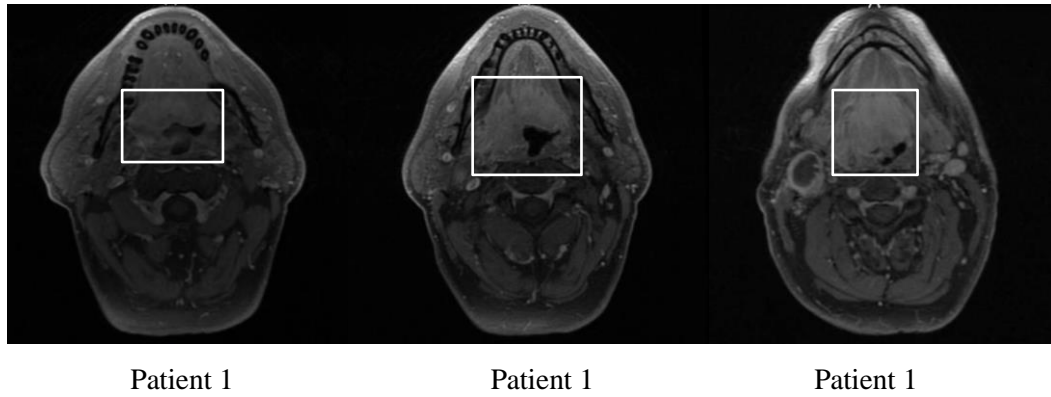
Typical real axial (short-axis) T1+Gd MRI slices from a single patient with oropharynx tumour (white outline). Dissimilar intensity (grey-level) values for same tissue type (for example: tumourous tissue) can be observed due to non-uniform coil sensitivity.
